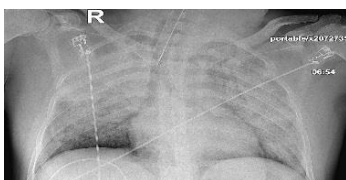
Chest x-ray in AP view demonstrated diffuse bilateral infiltration, especially in upper lobes, without any evidence of pleural effusion
